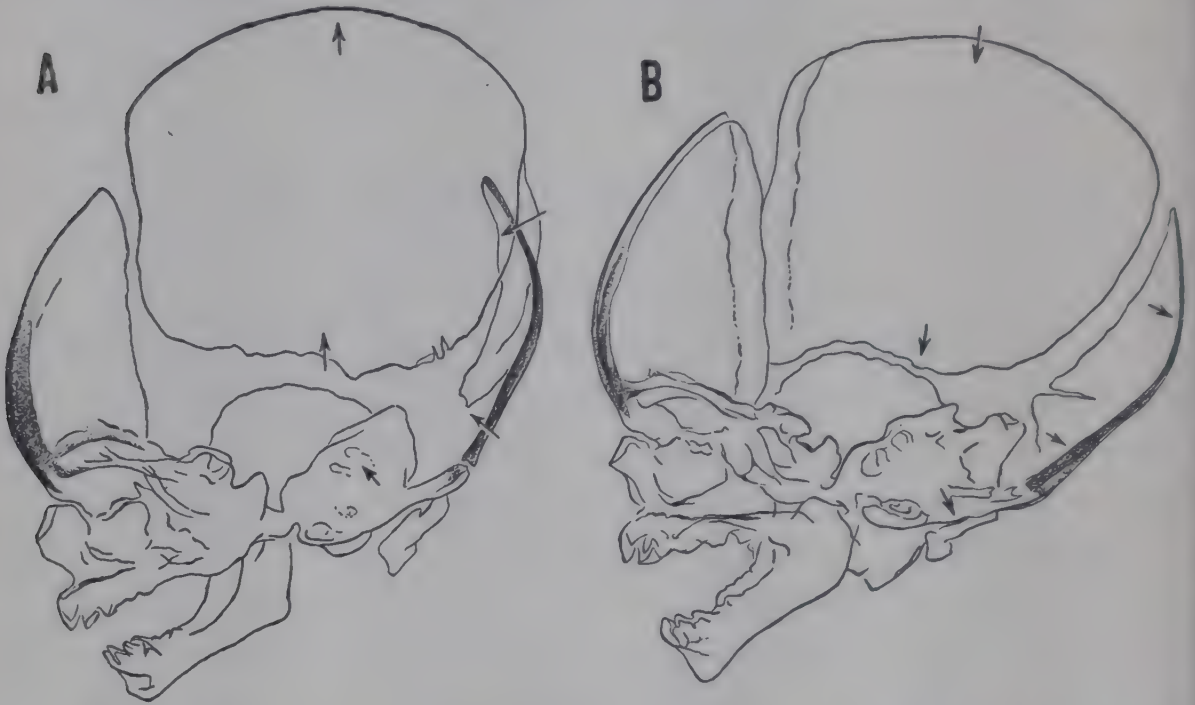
A*, tracing of roentgenogram of neonatal skull on first day of life, demonstrating molding of bones of the calvarium with overlapping of their edges and narrowing of sutures caused by compression during passage of head through the birth canal. Parietals are displaced upward and temporals and occipital are rotated counterclockwise. *B*, tracing of roentgenogram on third day of life, showing re-expansion of cranium and widening of sutures and fontanelles, as compared with *A*, after parietal, occipital and temporal bones have returned to normal positions. (Courtesy of Dr. H. C. Moloy; from Caffey, J.: *Pediatric X-ray Diagnosis* [2d ed.; Chicago: Year Book Publishers, Inc., 1950].)
